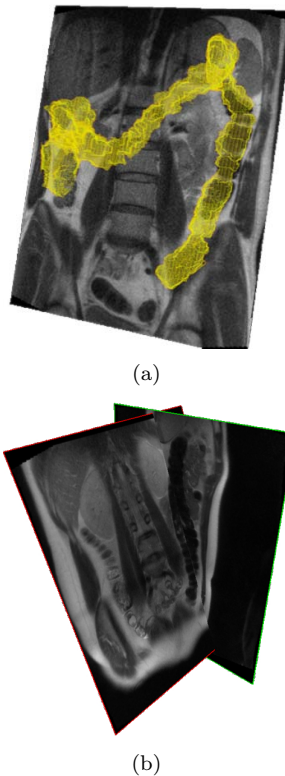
(a) Fusion of dynamic 2D and static 3D. (b) Multi-plane MRI showing the colon motion in three dimensions.
